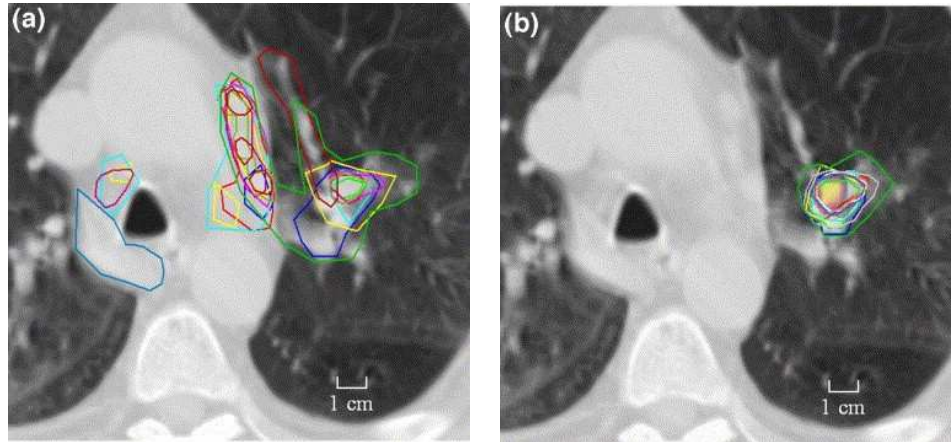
Comparison of tumor volume delineation using (a) CT only and (b) matched PET/CT by the same 11 radiation oncologists (Figure from [92]).
